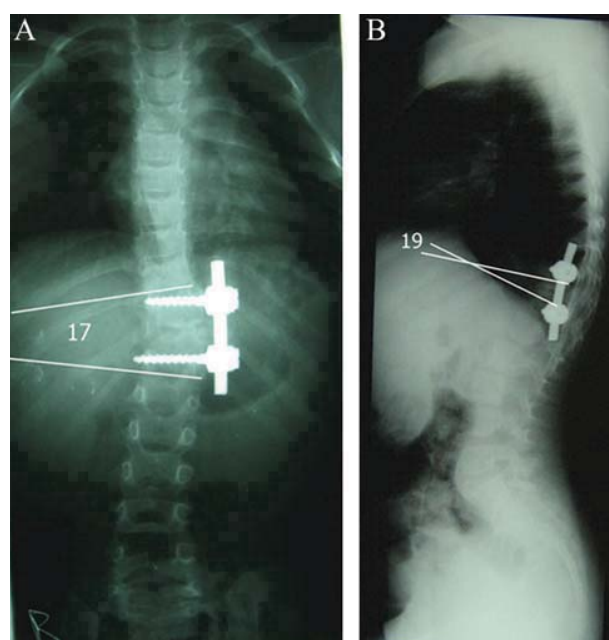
A, B, Two years and 8 months follow-up anteroposterior and lateral radiographs showing a residual scoliotic deformity measuring 17° and a kyphotic deformity measuring 19°.
